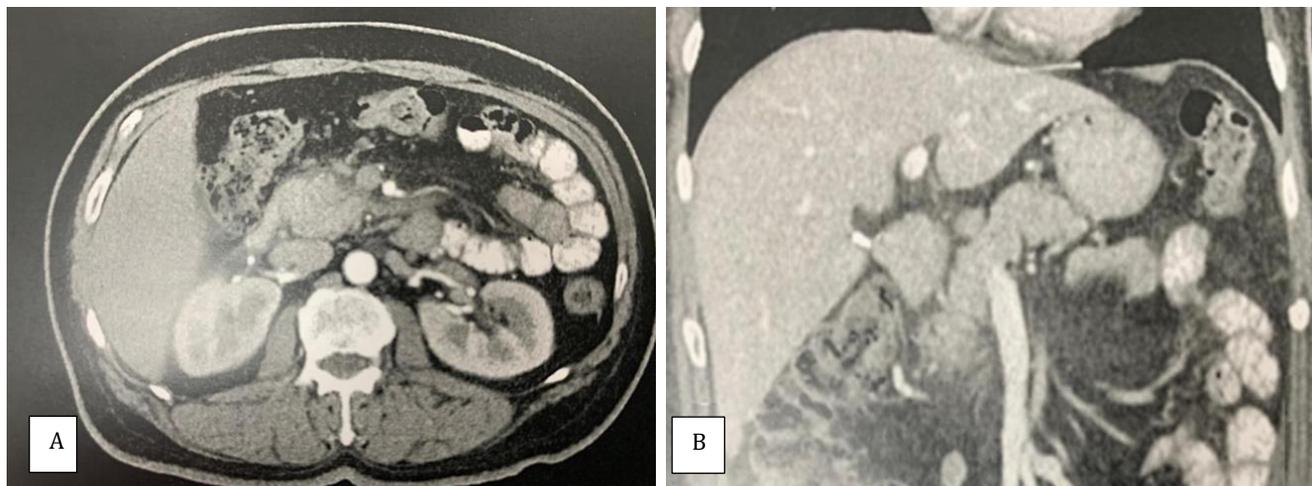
Axial (A) and coronal (B) planes of CT scan of the patient's abdomen, on his initial assessment, showing an enlarged pancreas (Arrow) with indistinct margins and reduced density (due to oedema) with surrounding fat stranding.
